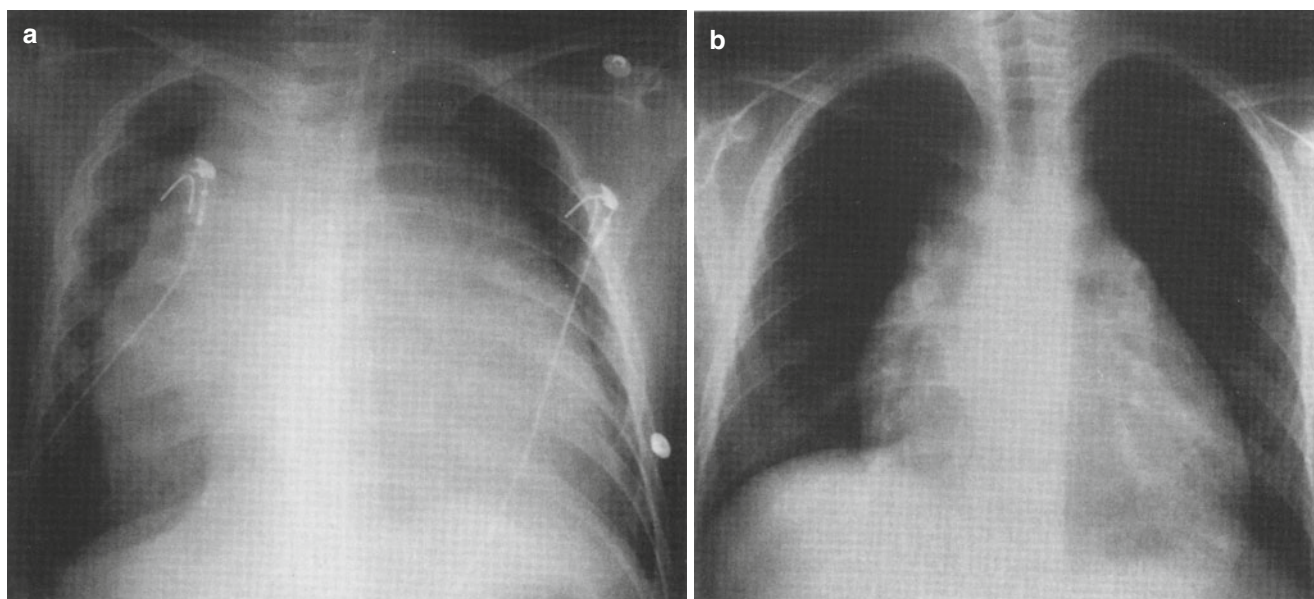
(a) Chest radiograph of an 8 year old girl who presented with a 3 week history of wheezing, cough, anorexia and weight loss of 3 kg. The pleural effusion was tapped to avoid biopsy and the diagnosis of acute lymphoblastic lymphoma was obtained. (b) Chest radiograph 1 week after the first course of prednisone, vincristine, doxorubicin, methotrexate, and intrathecal cytosine arabinoside (ara-C) demonstrates a dramatic response to therapy
